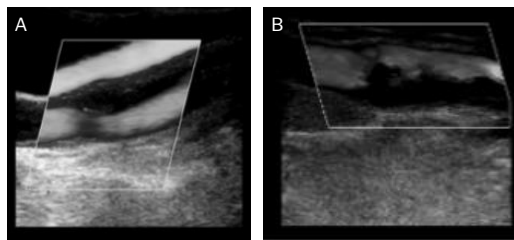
Ultrasound features of high-risk plaques. A) Hypoechoogenicity B) Plaque irregularity
